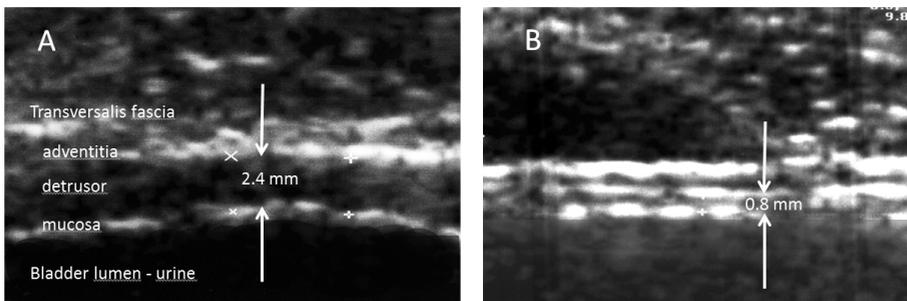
Ultrasound images of the anterior bladder wall with a 7.5 MHz array in two men with lower urinary tract symptoms. Enlargement 9.8 times, bladder filling in both men approx. 350 ml. The detrusor appears hypoechoogenic and is sandwiched between the hyperechoogenic mucosa and adventitia<sup>19</sup>. Detrusor wall thickness (DWT) is measured from the inner border of the mucosa until the inner border of the adventitia (+). Figure 1A is taken from a patient with mild bladder outlet obstruction (Schäfer grade 3) and normal bladder contractility ( $W_{\max}$  11.2  $W/m^2$ ); DWT 2.4 mm. Figure 1B is from a patient without bladder outlet obstruction (Schäfer grade 1) but with detrusor underactivity ( $W_{\max}$  3.4  $W/m^2$ ); DWT 0.8 mm.
